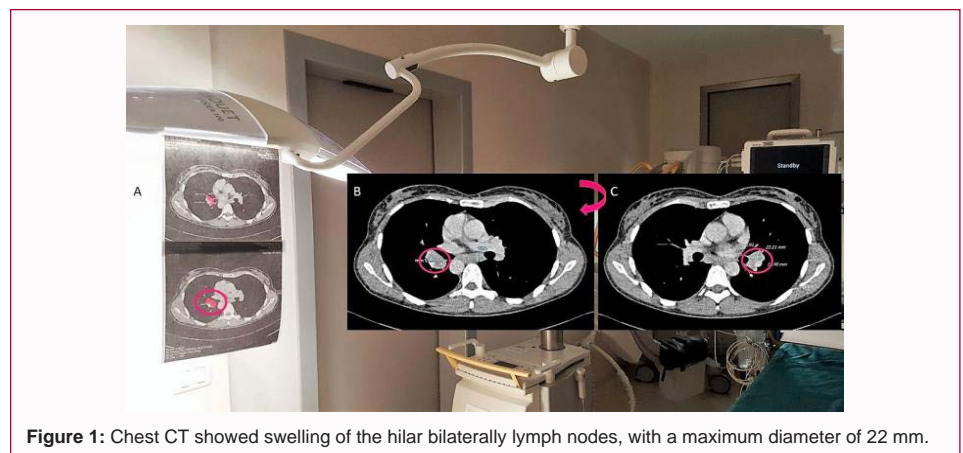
Chest CT showed swelling of the hilar bilaterally lymph nodes, with a maximum diameter of 22 mm.
